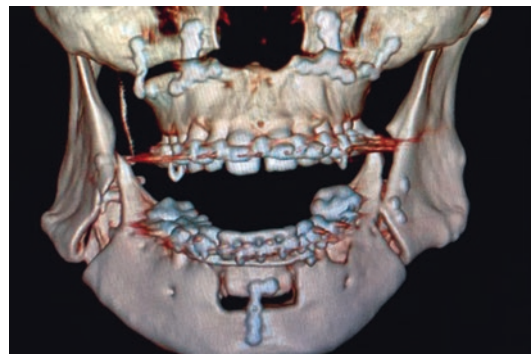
CT 2 month post-op, showing a fracture of the buccal plate. This segment presented an avascular necrosis
